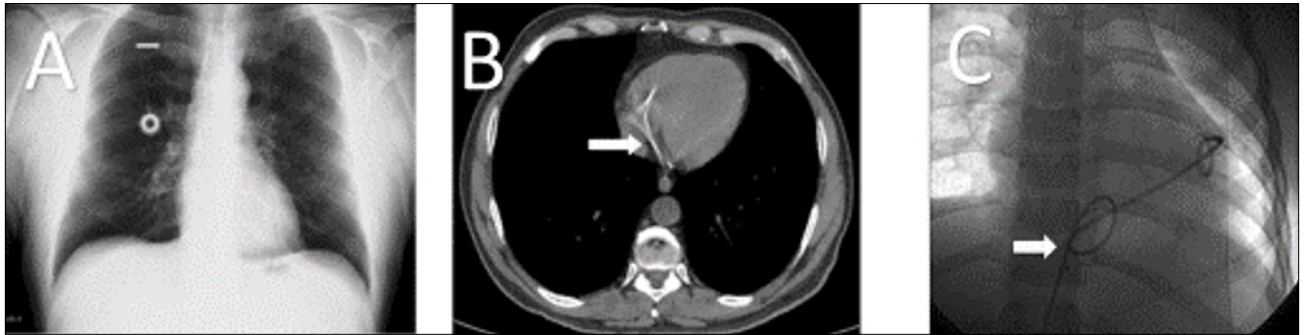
(A) Pinch-off syndrome due to chronic compression between the clavicle and the first rib (X-ray imaging), (B) Part of a fractured catheter is seen in the heart on a computed tomography scan, (C) Fractured part of a catheter removed under angiography from the right ventricle.
